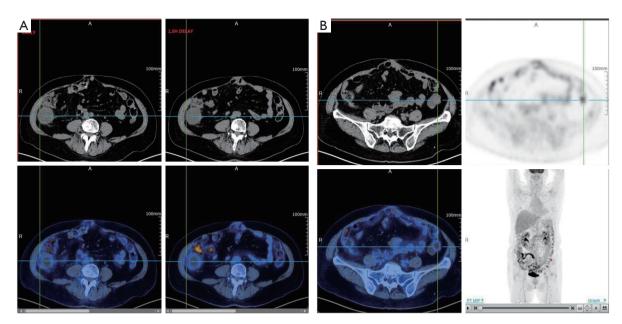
PET-CT images on June 12, 2018. (A) Cystic foci, about 45.5 mm \times 42.3 mm, were shown in the paracolic sulcus in the right middle abdominal cavity. There was increased glucose metabolism in the marginal area, with a maximum SUV of 4.4. (B) A cystic-solid space-occupying lesion of approximately 33.1 mm \times 30.3 mm was seen in the left iliac fossa. The solid area showed increased glucose metabolism, with a maximum SUV of 6.2. PET-CT, positron emission tomography/computed tomography; SUV, standardized uptake value; A, anterior; R, right.
